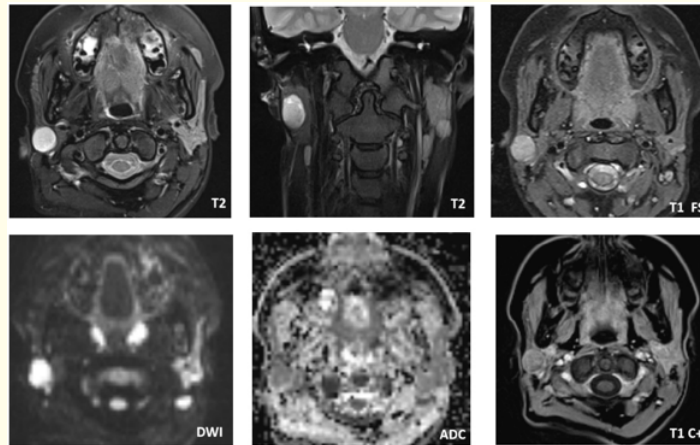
Parotid MRI showing a well-circumscribed right parotid mass, hyperintense on T2 and T2 FAT-SAT sequences, hypointense on T1, with diffusion hypersignal and slightly low ADC values (0.9 to 1×10^{-3} mm²/s). Mild peripheral enhancement was observed after gadolinium administration.
